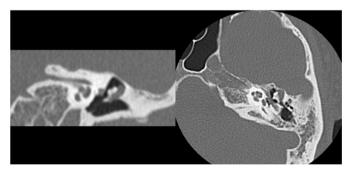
Preoperative temporal bone CT images of case 1. A persistent soft-tissue shadow is seen lateral to the head of the malleus and the body of the incus. CT, computed tomography.
